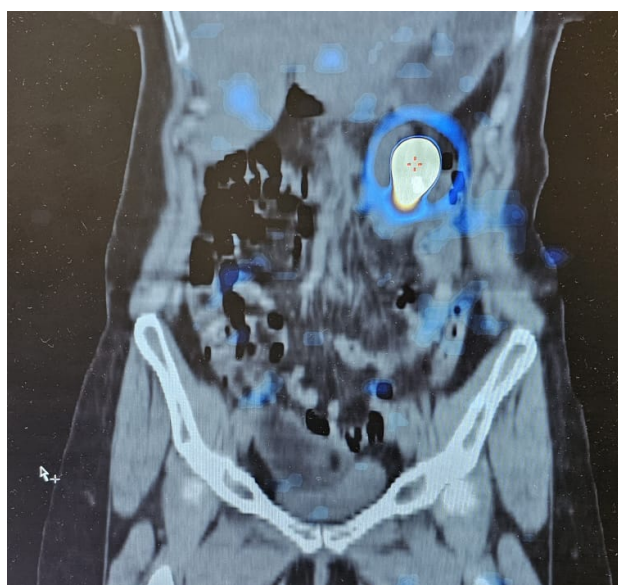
SPECT-CT image of Patient 7 showing a halo around the injection site (red crosshair) at the SF, situated close to the midline abdominal vasculature.
